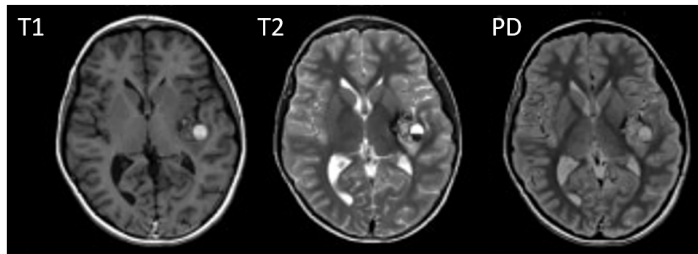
MRI of the brain. From left to right T1, T2 and PD images.
